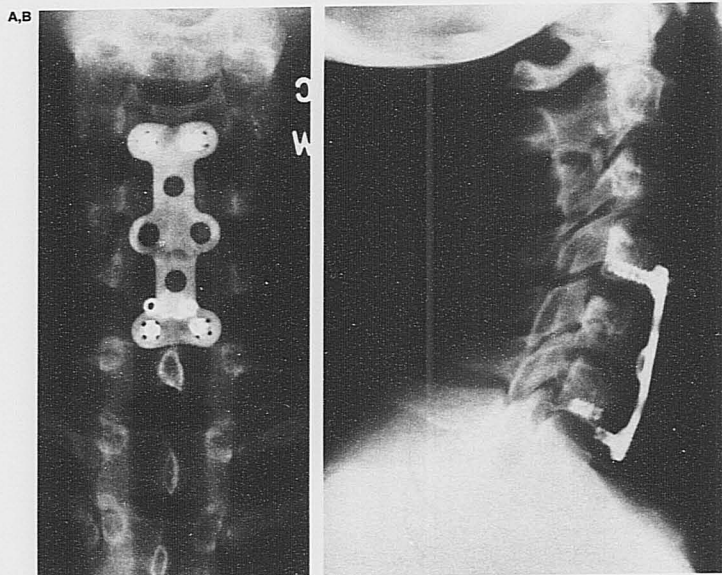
A and B: Anteroposterior and lateral radiographs from case 1 demonstrate bilateral fracture of fenestrated inferior screws and line of pseudoarthrosis 3 months after surgery.
